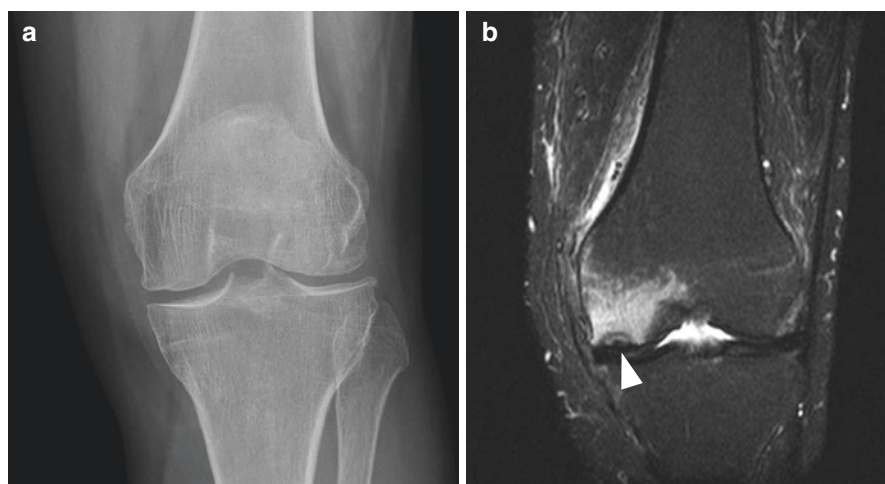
Osteonecrosis plain radiography vs magnetic resonance imaging
